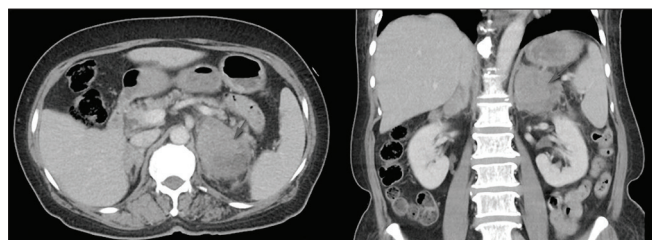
Enhanced abdominal computed tomography showing hypodense bilateral adrenal gland tumors (arrow) with left predominance (6.3 cm)
